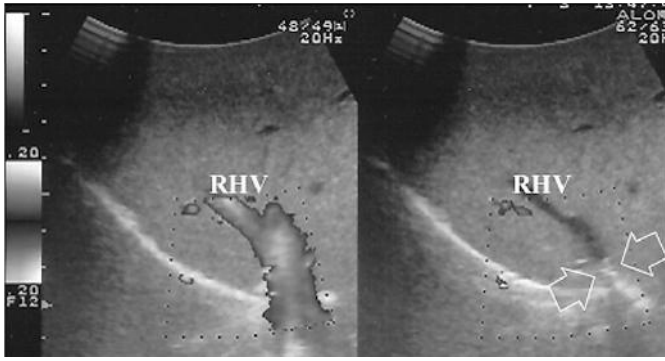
a) at IOUS the caval confluence of the right hepatic vein (RHV) is visualized and color-Doppler shows a regular flow (blue colour); b) the surgeon position his fingers at the level of RHV caval confluence without for that having had to skeletonize the RHV, and with the fingers themselves bluntly compress the RHV (arrows): the temporary occlusion of the vessel can be well confirmed by the disappearance of any sign of blood flow at color-Doppler IOUS.
